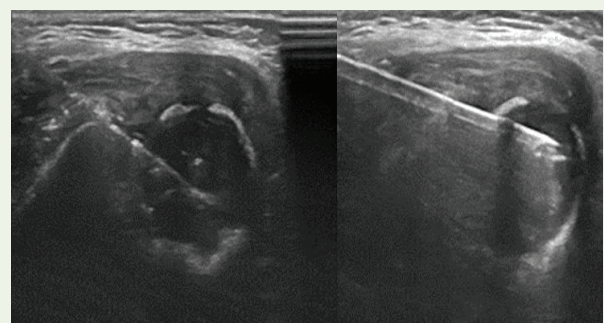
Sagittal and axial ultrasound image showing a well-circumscribed, expansile lesion in the body of left mandible with low echogenicity and internal vascularity having significant destruction of both the cortical and medullary bone surfaces of the mandible.
